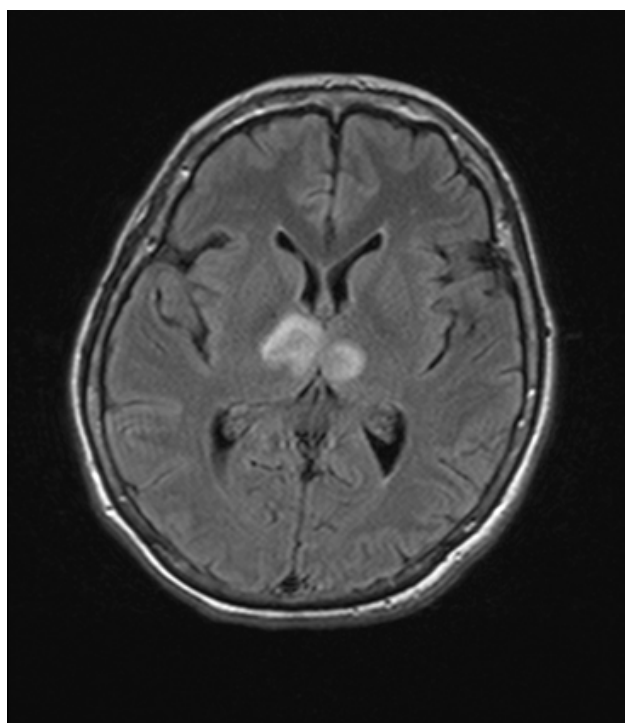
MRI demonstrating bilateral, symmetrical thalamic infarction
